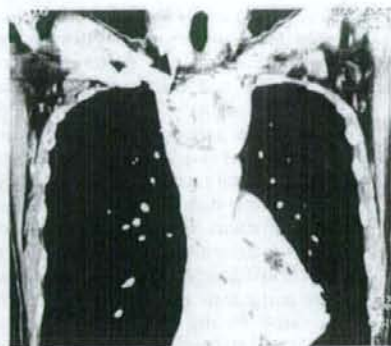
A 55-year-old woman with Type A in Masaoka stage I. CT showed a clear demarcation at the anterior mediastinum and an evident tumor outline in the internal wall structure. The ^{18}F -FDG PET examination showed that ^{18}F -FDG accumulation in the tumor was slightly more pronounced than that in the mediastinum. The T/M ratio was 2.12.
